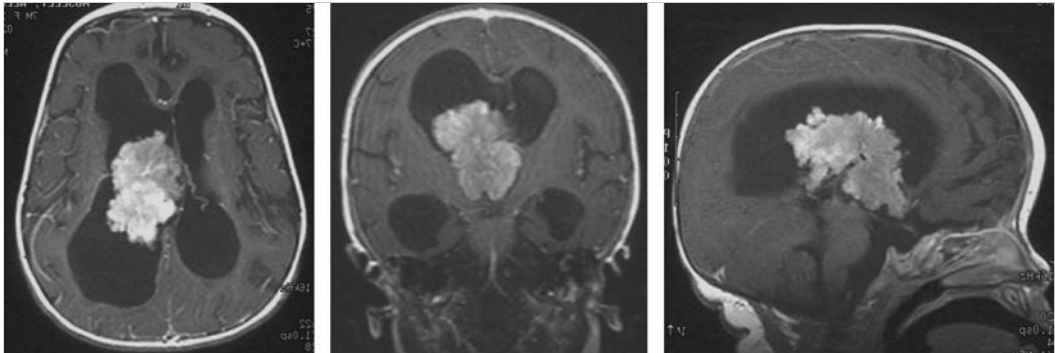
Postcontrast T1-weighted MR images depicting large intraventricular mass with associated ventriculomegaly.
